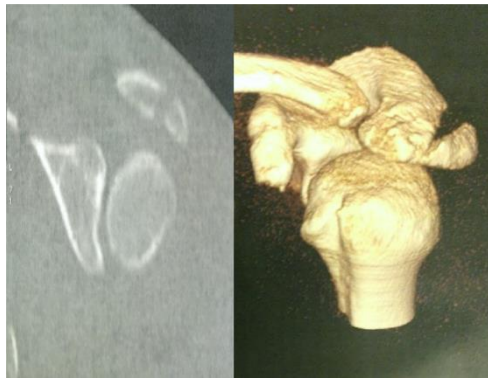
CT Scan shows displaced fracture of posterior angle of acromion process.
